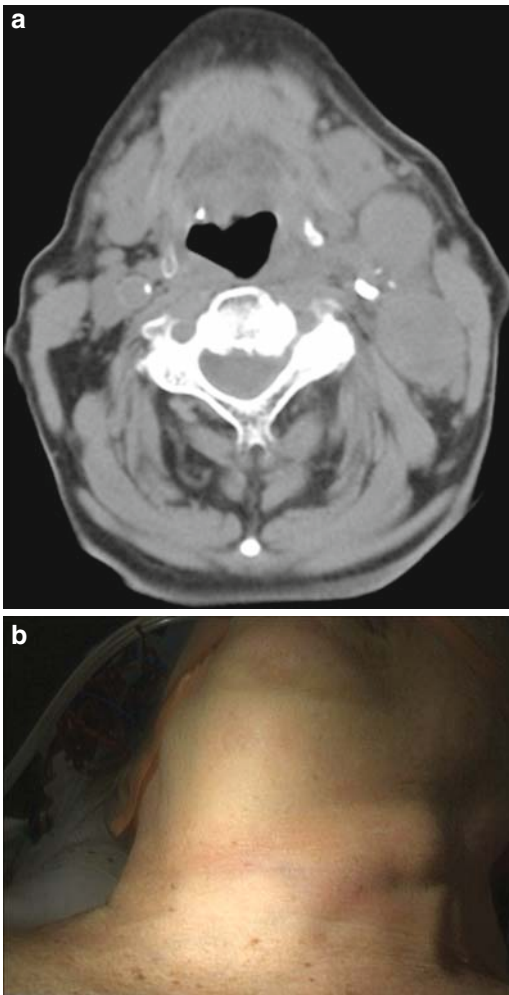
(A, B) CT Neck demonstrating tall cell variant of papillary thyroid cancer with extensive adenopathy.
